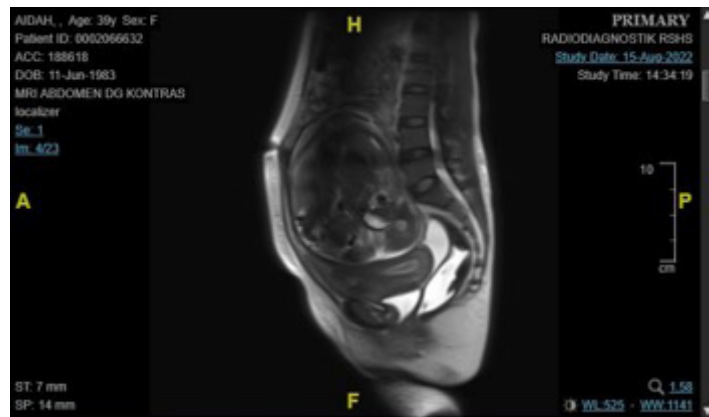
Magnetic resonance imaging slice
